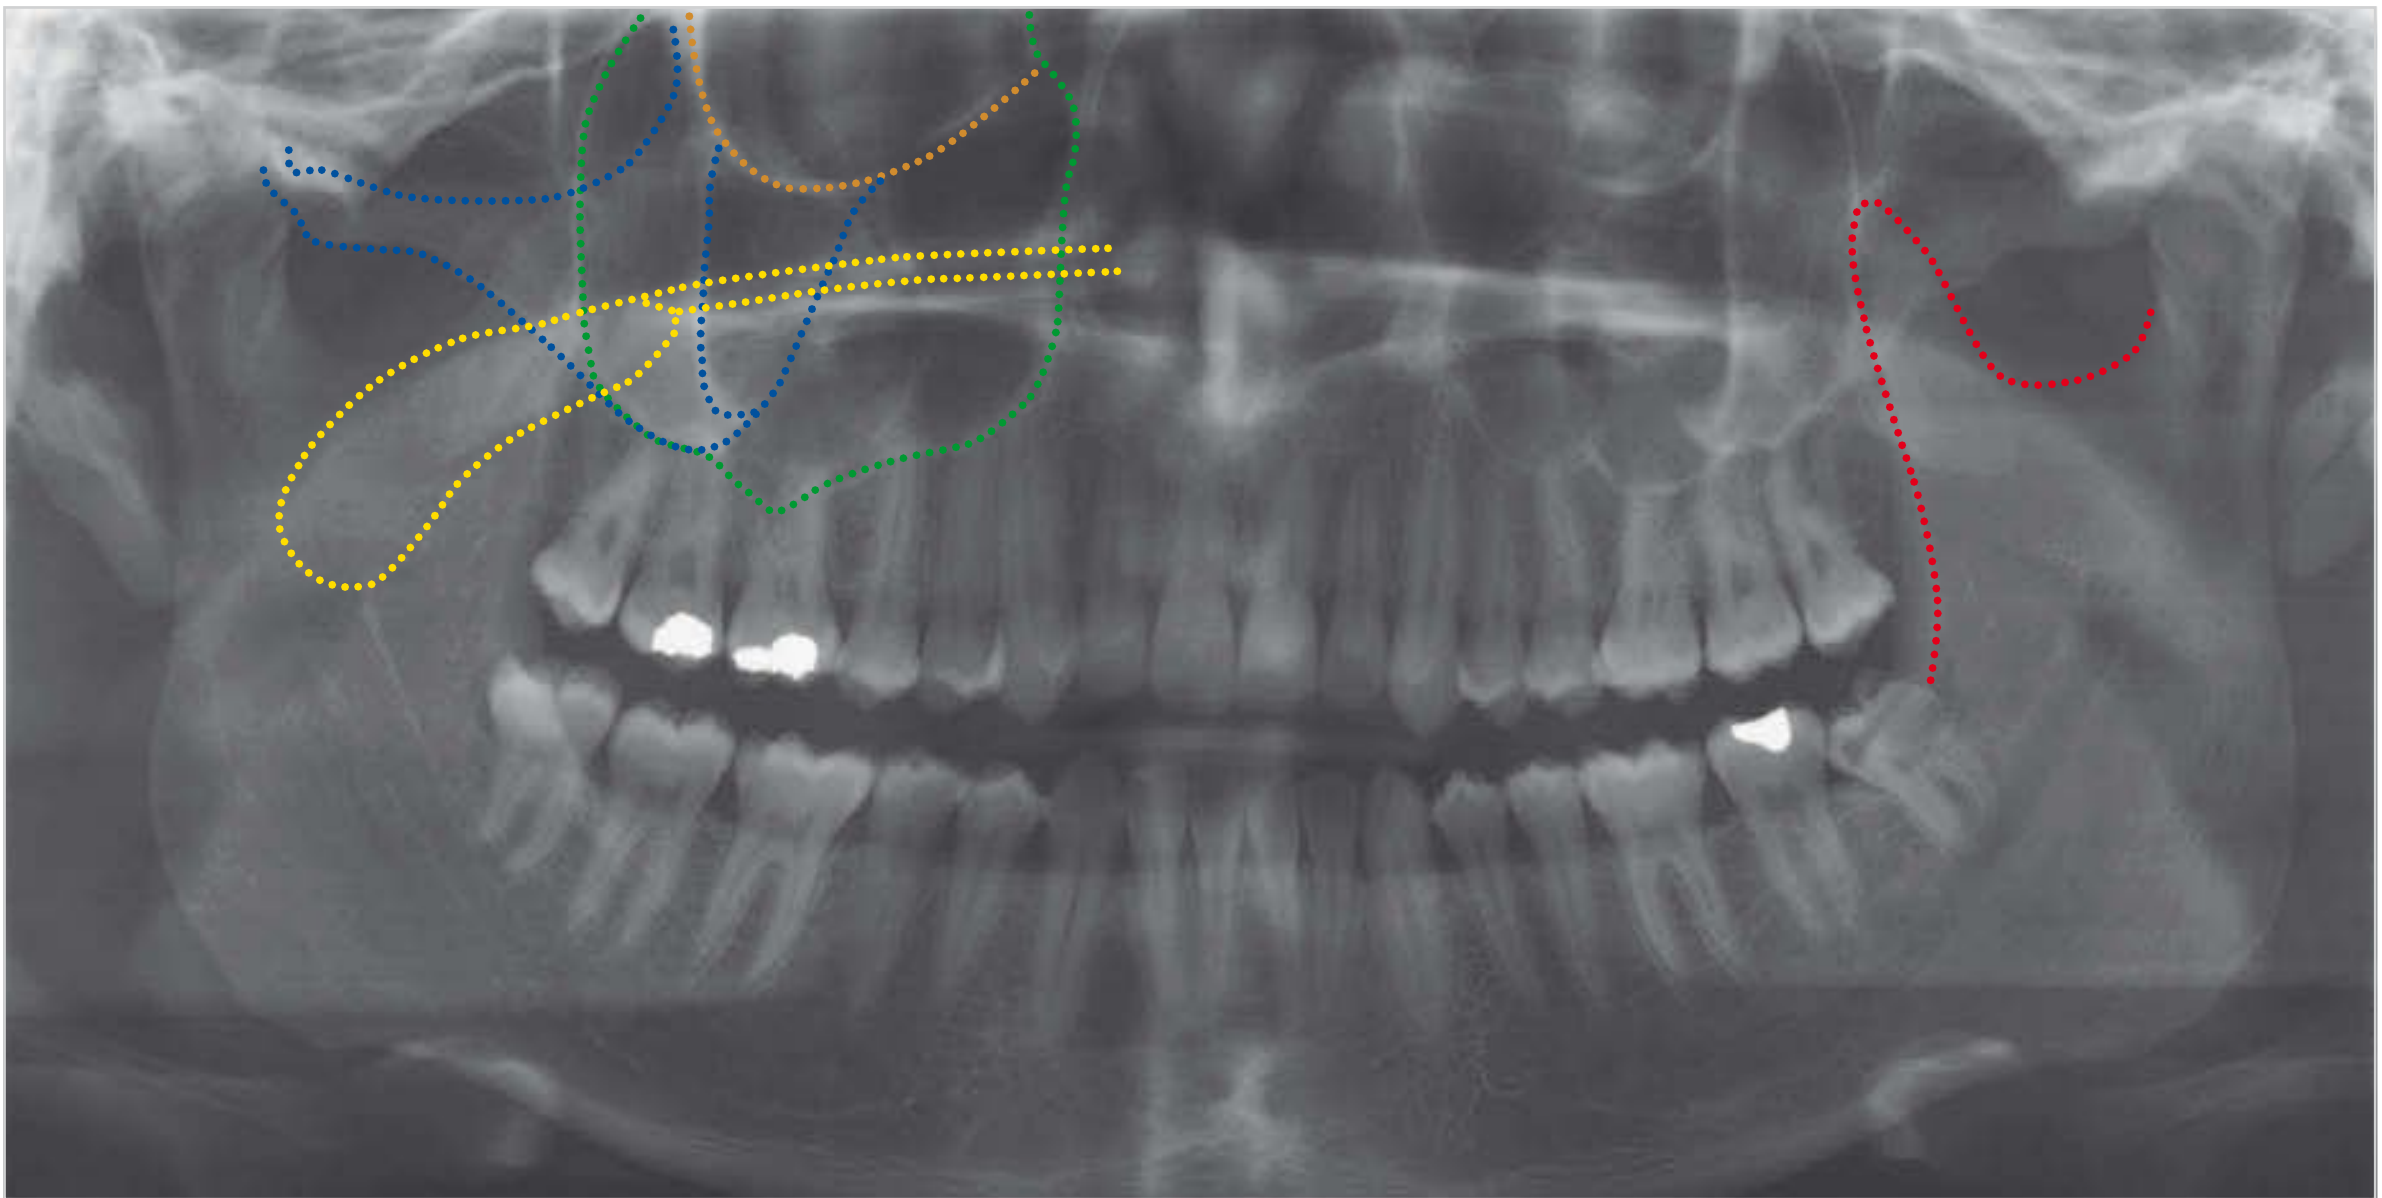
The zygomatic bone, coronoid process, maxillary sinus, and nasal cavity superimpose on each other in the lateral maxillary and midfacial region. This makes radiographic diagnosis difficult, if not impossible. Blue: zygomatic bone; yellow: hard and soft palate; green: maxillary sinus; brown: orbit; red: coronoid process.
